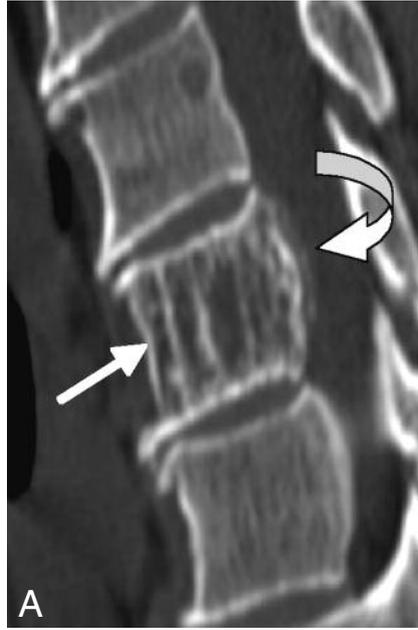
Respectively sagittal (A) and axial (B) reformatted CT images. Typical thickened trabeculations and hypodense, fatty components confirms the diagnosis of a common vertebral haemangioma (white thin arrow). CT scan reveals also the 'sunburst' calcifications (curved arrows) of the extra-osseous components as for hemangioma of the skull.
